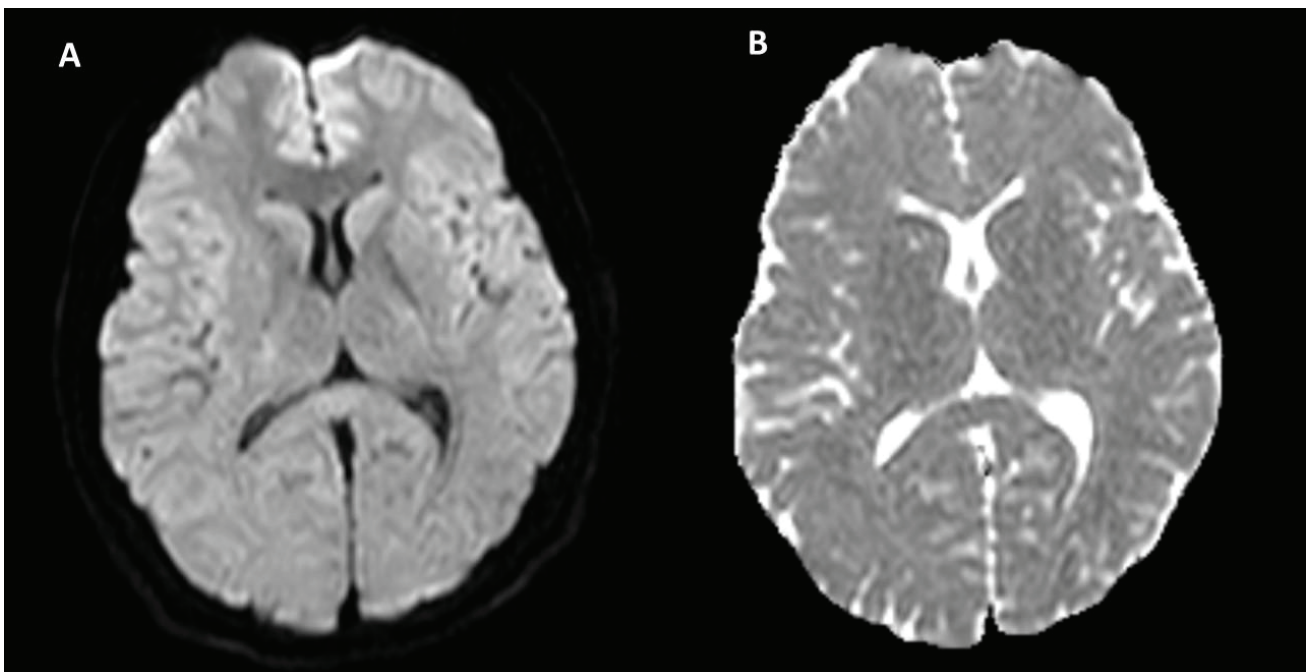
The Cranial MRI, performed one week after admission, showing the total resolution of the lesion (A; DWI sequence, B; ADC sequence).
